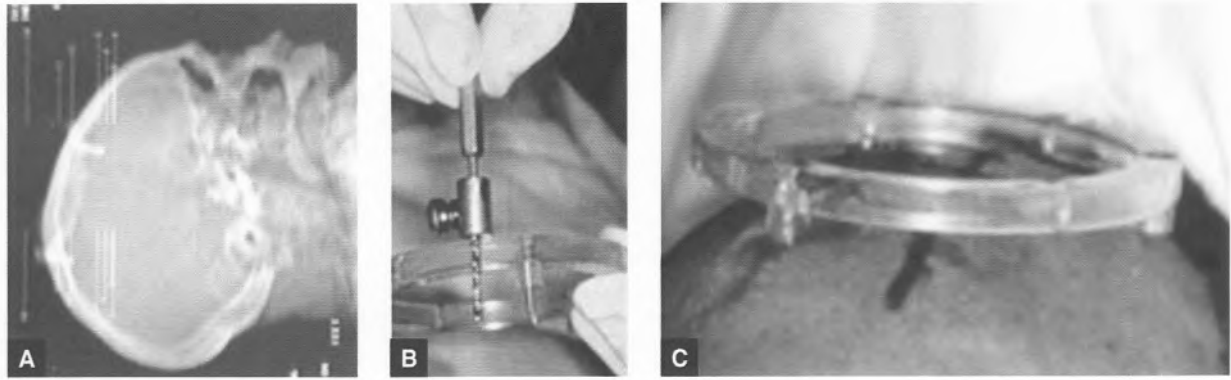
Skull-mounted halo, attached with screws. CT surview showing the halo secured with two screws (a); these had been placed using a hand-held power tool with a depth stop to prevent plunging (b). Insertion of the screws resulted in secure cranial fixation of the halo (c).
